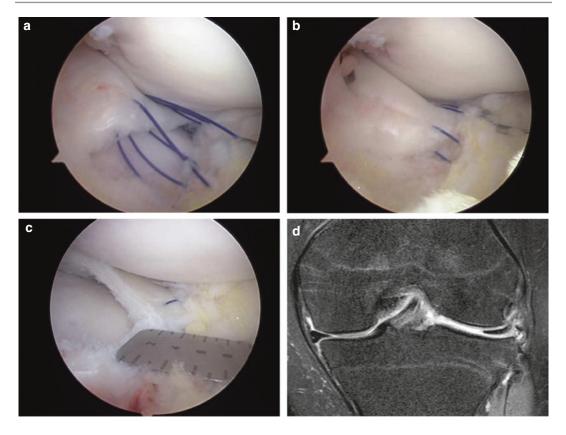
a, b The torn meniscus is reduced by pulling 3 stitches of the No. 0 PDS, which now holds the circumferential fibers of the meniscus. c After partial meniscectomy with repair, peripheral rim of lateral meniscus was preserved with 9-10 mm that is the similar size of the midbody of medial meniscus. d coronal magnetic resonance imaging shows complete healing of the tear site with a lateral meniscus of normal shape at 6 months' follow-up
